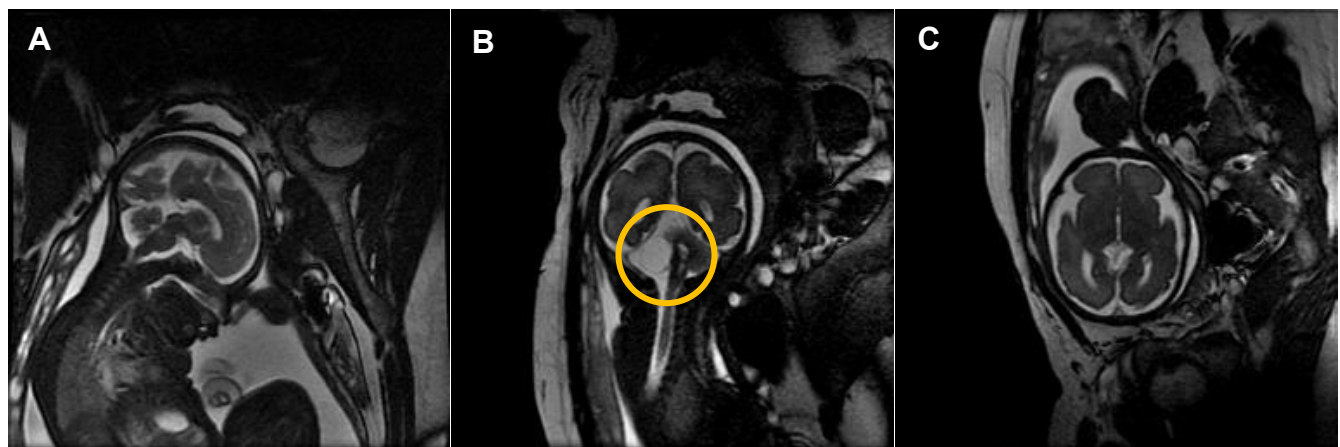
MR images of 30-week-old fetus. (A) Sagittal. (B) Coronal. (C) Axial FIESTA™. Note the cystic posterior fossa lesion on the coronal image (circle).
